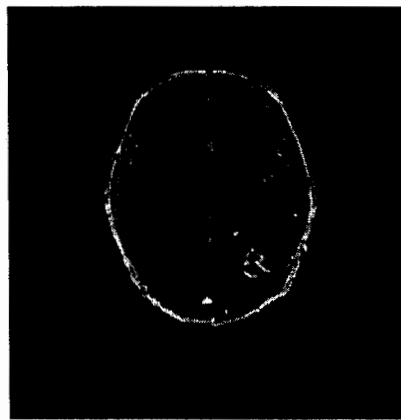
Registered MR image of brain with PET by Image Registration described by Huang et.al
